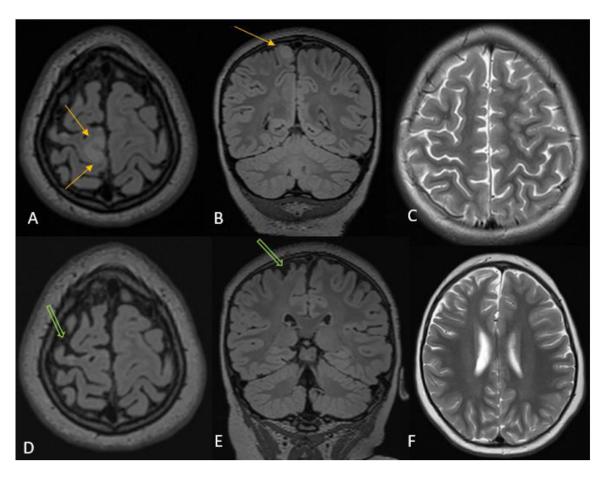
(A-C) Follow-up MRI 2 months after initial imaging shows a new T2 hyperintense lesion in the paramedian posterior frontal lobe (A, B- axial, coronal FLAIR – yellow arrows) and subtle right frontoparietal volume loss (C- axial T2W). (D-E) Second follow-up 7 months later showed interval resolution of the right posterior temporal T2 hyperintense lesion with new atrophic change (D, E) axial, coronal FLAIR – open arrows) and more widespread progression of volume loss in the right frontal lobe (C – axial T2).
